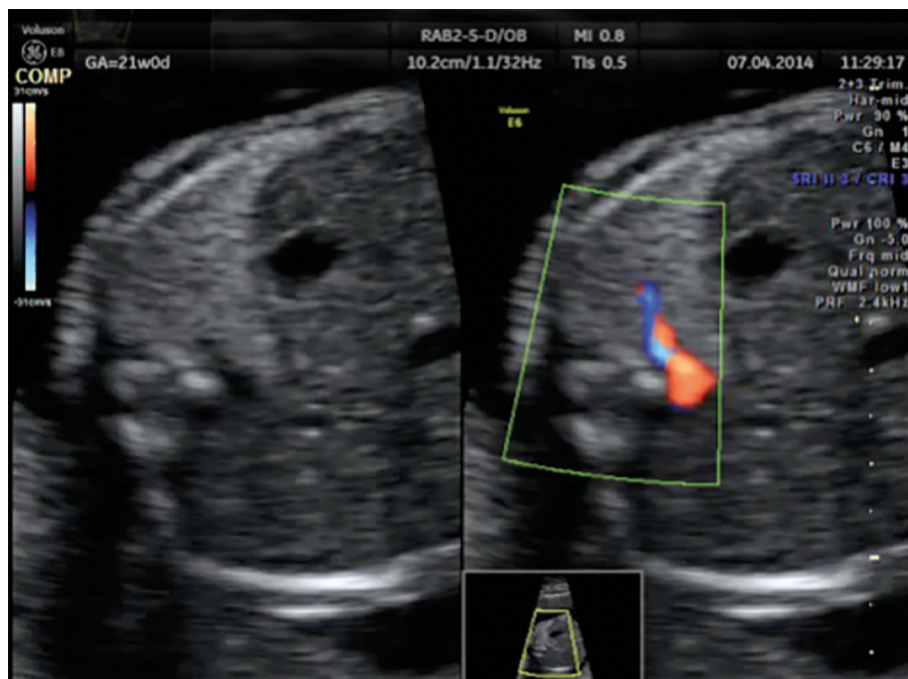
Fetal left lung sequestration and the feeding vessel on color Doppler imaging
